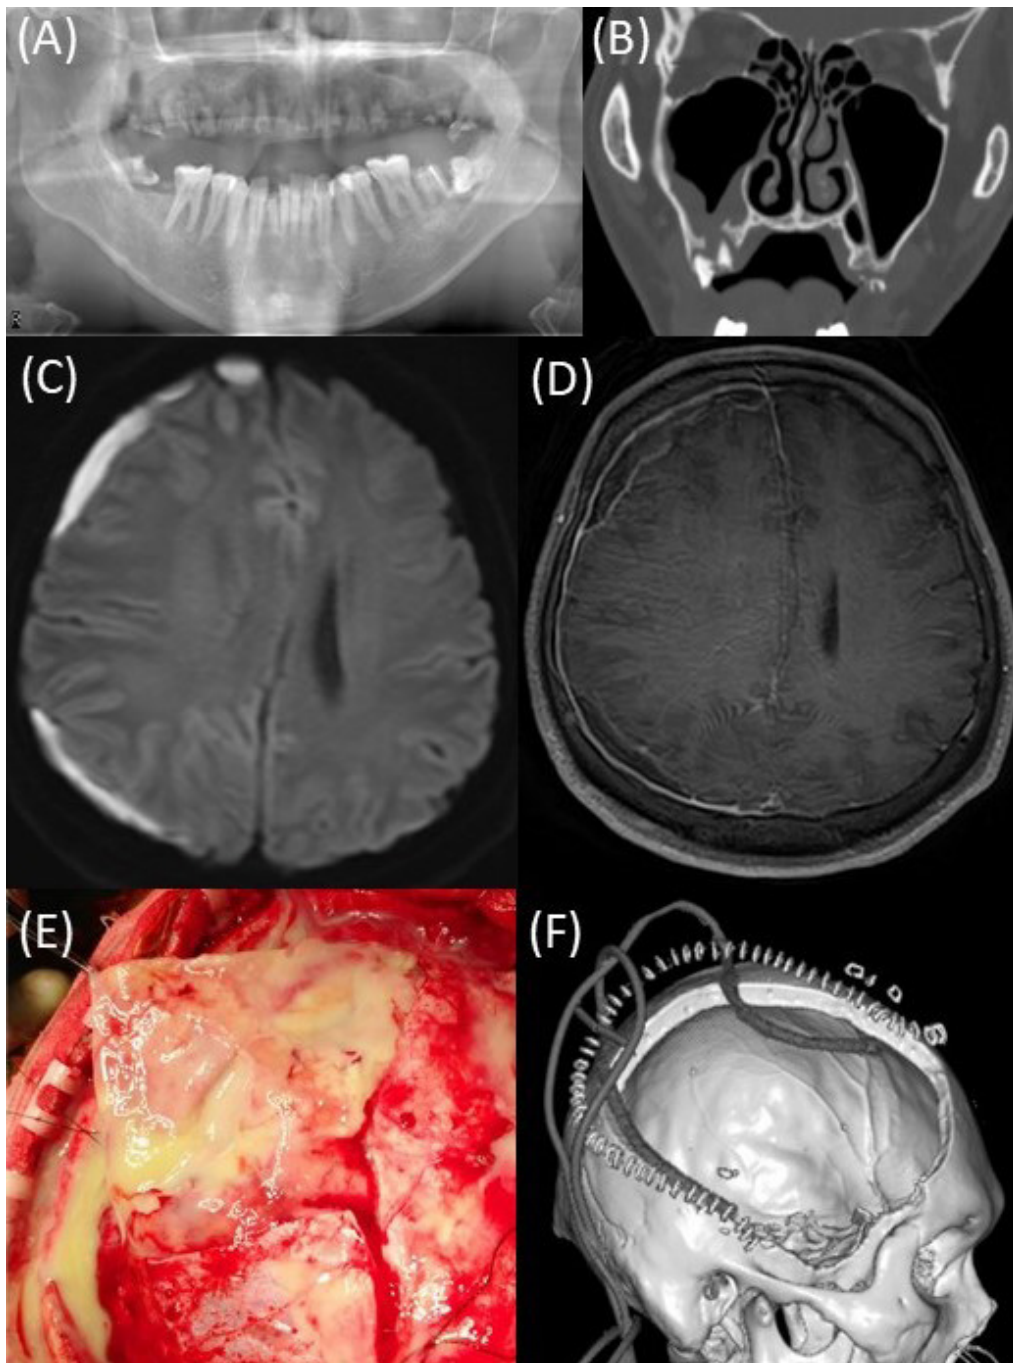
A. Poor dentition was identified using dental X-rays. B. Bone window coronal-head Computed Tomography (CT) scan reveals an interruption of the right maxillary sinus floor corresponding to the alveolar process. C. Diffusion-weighted Magnetic Resonance Imaging (MRI) reveals a massive subdural empyema affecting the right cerebral hemispheres and a midline shift. D. T1-weighted-with-gadolinium MRI reveals the right cerebral hemispheres and dura with high, intense peripheral gadolinium enhancement. E. Intraoperative imaging shows the flow of pus from the subdural space. F. Postoperative three-dimensional CT shows the decompressive craniotomy and drainage tube.
